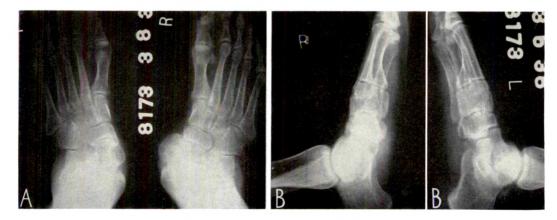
Latest roentgenograms. A, March 8, 1938, and B, March 5, 1938, demonstrating increased density of right astragalus.
